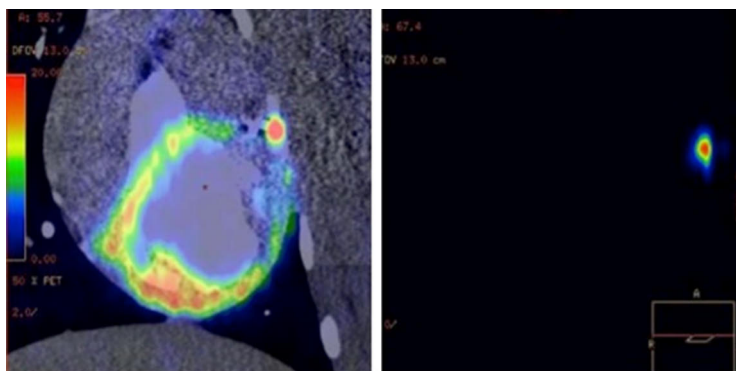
Minipig study (Study II). On left is fused CTA and PET images: the coronary plaque can be distinguished from the background activity. On right is PET only image: the hot coronary plaque is easily visible without background activity.
